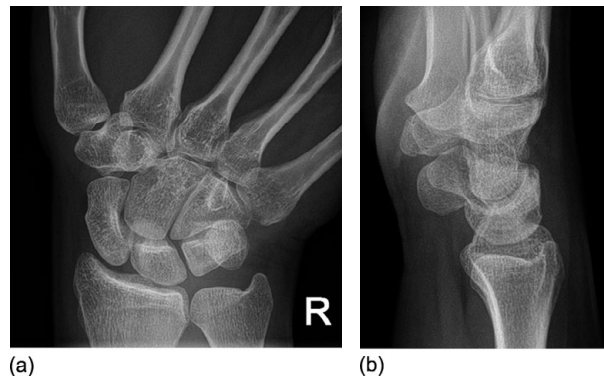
(a) Posteroanterior and (b) lateral radiographic projections
